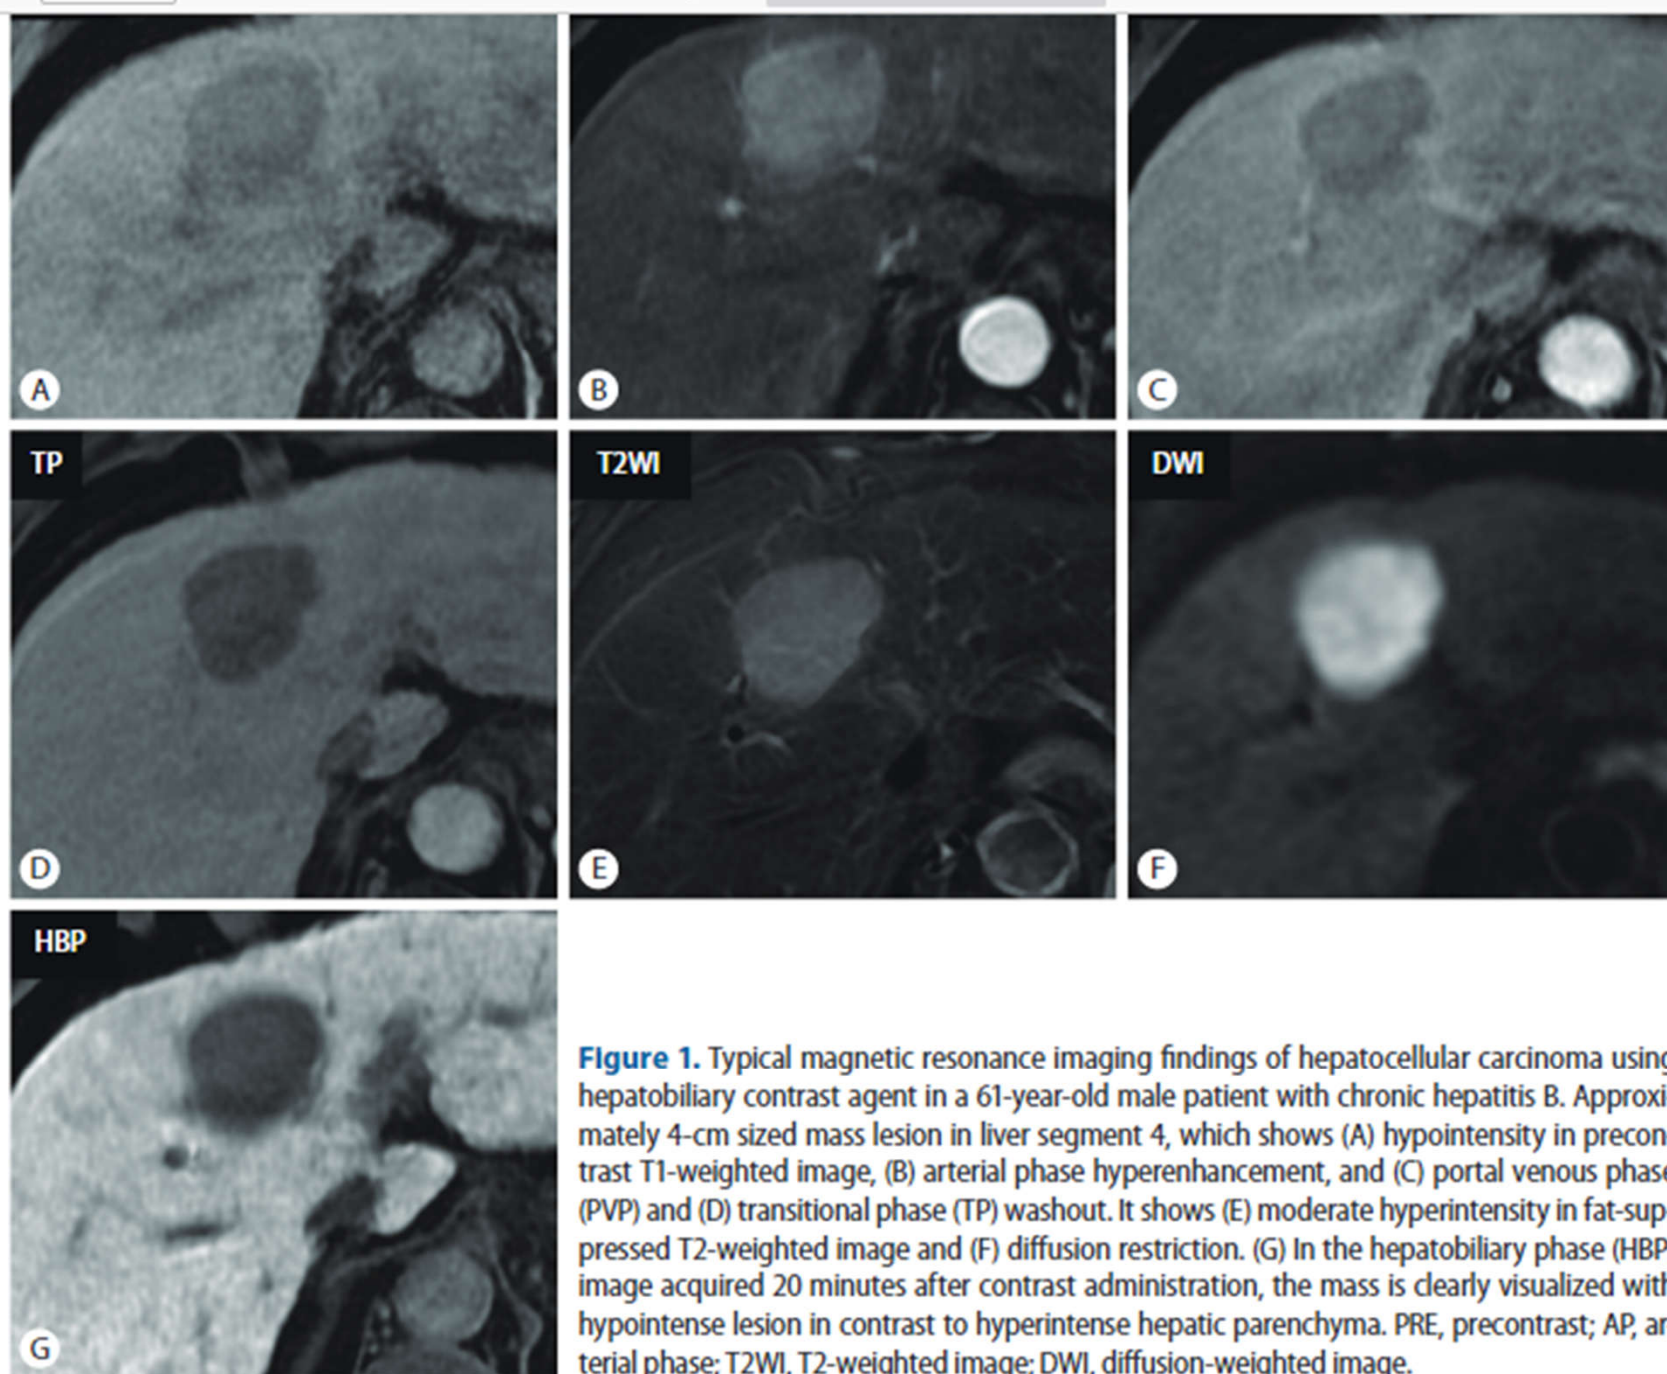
Typical magnetic resonance imaging findings of hepatocellular carcinoma using hepatobiliary contrast agent in a 61-year-old male patient with chronic hepatitis B. Approximately 4-cm sized mass lesion in liver segment 4, which shows (A) hypointensity in precontrast T1-weighted image, (B) arterial phase hyperenhancement, and (C) portal venous phase (PVP) and (D) transitional phase (TP) washout. It shows (E) moderate hyperintensity in fat-suppressed T2-weighted image and (F) diffusion restriction. (G) In the hepatobiliary phase (HBP) image acquired 20 minutes after contrast administration, the mass is clearly visualized with hypointense lesion in contrast to hyperintense hepatic parenchyma. PRE, precontrast; AP, arterial phase; T2WI, T2-weighted image; DWI, diffusion-weighted image.
